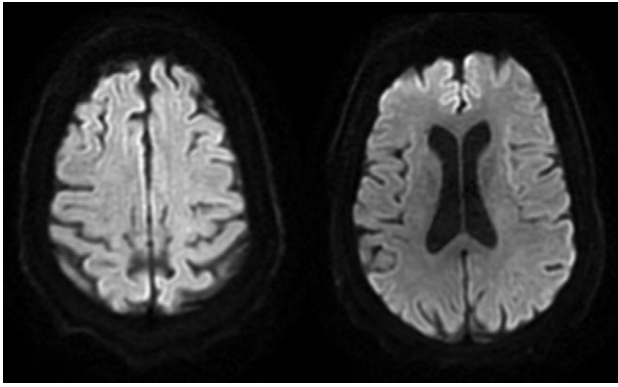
Diffusion weighted imaging of MRI showing no evidence of acute embolic stroke.
